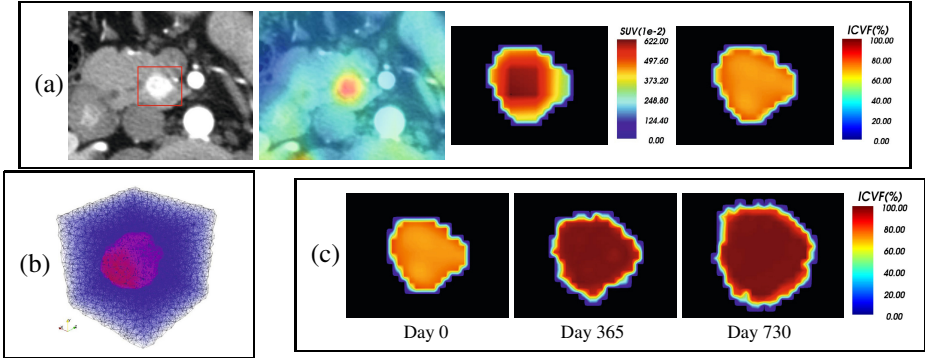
(a) Post-contrast CT, registered PET-CT, and the computed SUV and ICVF of the tumor (red box). (b) FEM mesh of a tumor (red) and its surrounding tissue (blue). (c) Ground-truth ICVF at three time points of a set of synthetic data ($\alpha = 3 \text{ mm}^3/\text{g}/\text{day}$).
